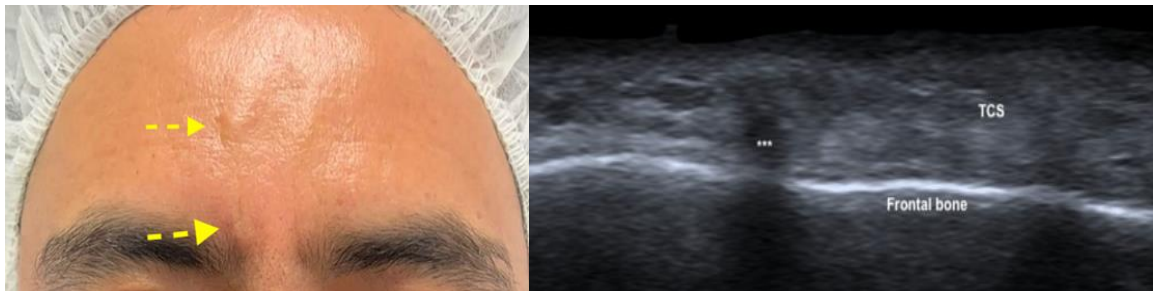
and 4B: Clinical image of visible and palpable threads indicated by yellow arrows. High-resolution ultrasound reveals the thread located in the subcutaneous tissue (SCT), with early foreign body reaction changes and posterior acoustic shadowing (asterisks *)
